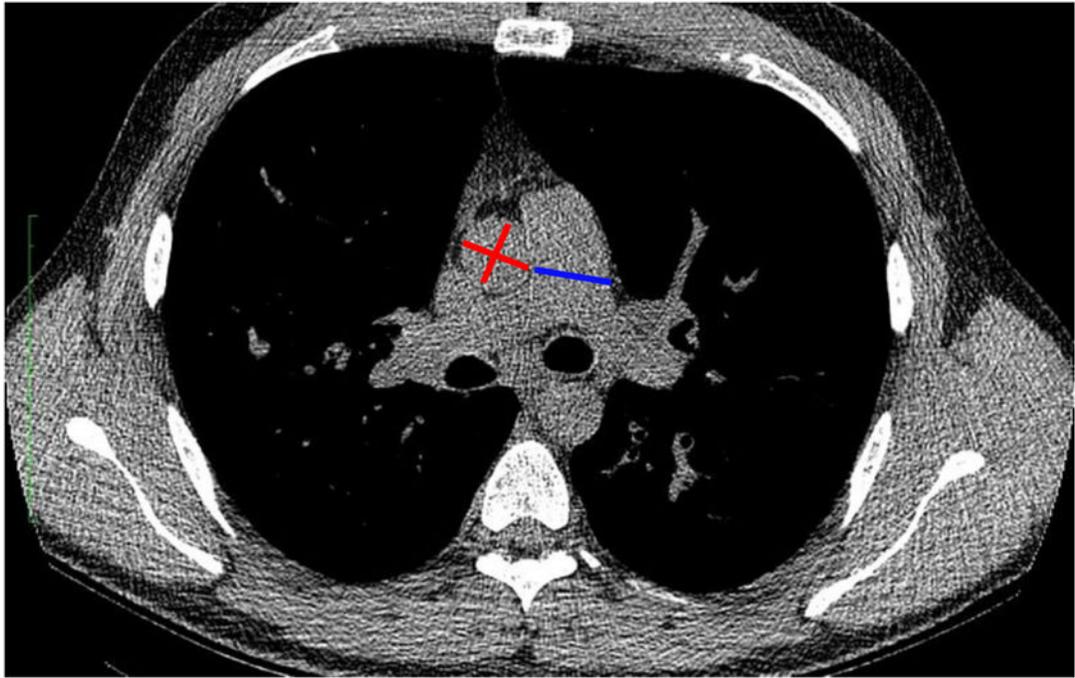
Representative measurements of the pulmonary artery and aortic diameters by CT scan
